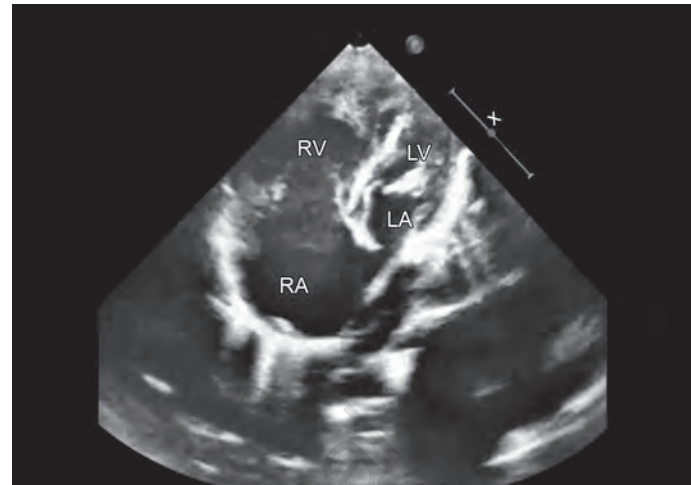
TAPVC: Apical four-chamber view showing a small LA and dilated RA/RV.
